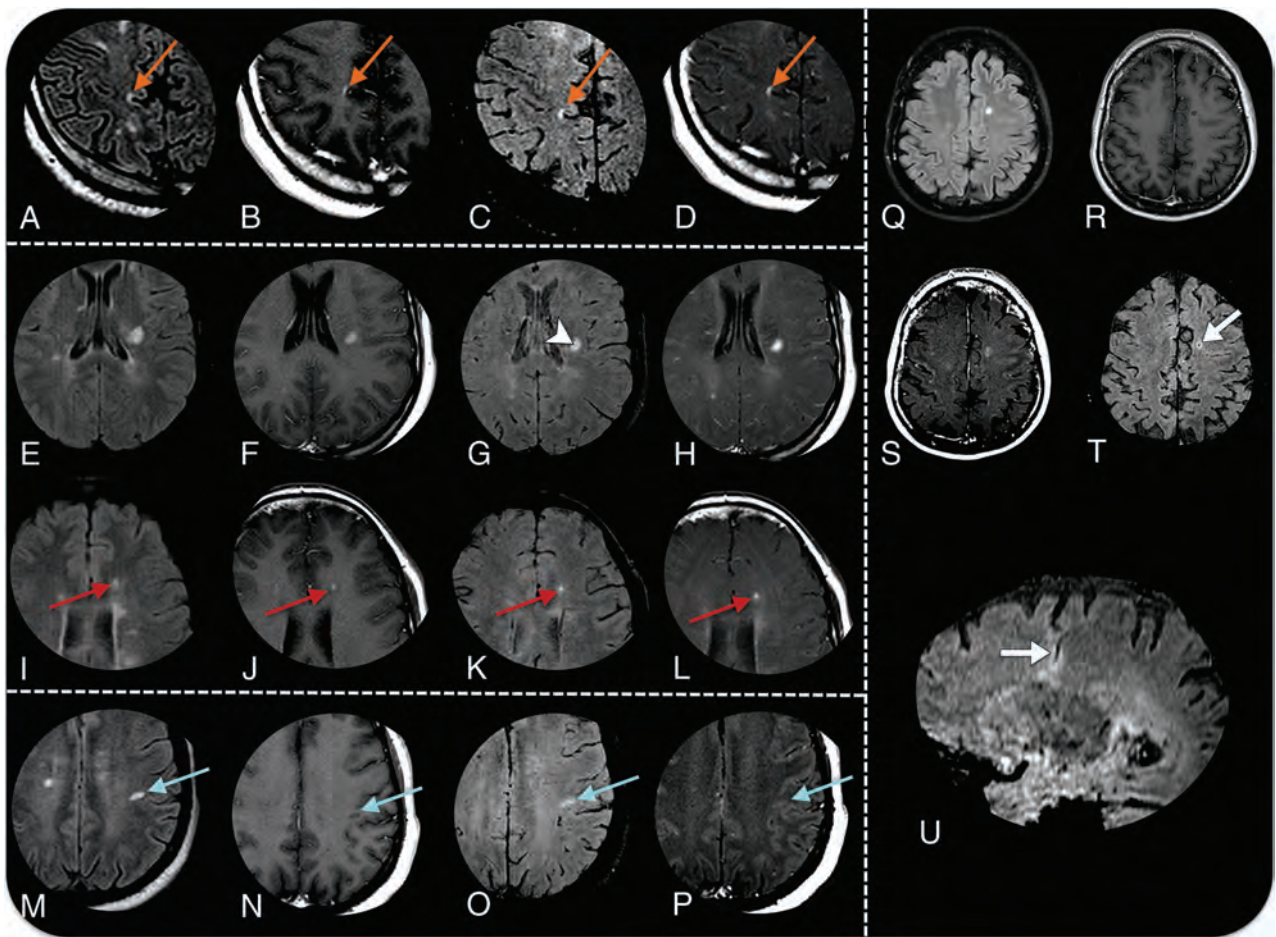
MR imaging detection of active plaques in 4 different patients with MS. Axial fluid-attenuated inversion recovery sequences (A, E, I, M, and Q), axial Gd-T1 SE sequences (B, F, J, N, and R), axial Gd-SWI sequences (C, G, K, O, and T), T1 Gd-T1 MTC sequences (D, H, L, P, and S), and a sagittal reformatting Gd-SWI sequence (U). Patient 1 demonstrates an acute juxtacortical/cortical demyelinating lesion in the right precuneus with Gd enhancement in all sequences (orange arrows in A–D). Patient 2 demonstrates an acute demyelinating plaque on the left corona radiata (E–F). Gd-SWI depicts the central vein within the plaque (arrowhead in G), adding specificity in favor of the demyelinating substrate. Similar to the Gd-T1 SE and Gd-T1 MTC sequences, the Gd-SWI sequence is also able to demonstrate BBB dysfunction in small lesions (red arrows in I–L). Patient 3 shows an acute demyelinating plaque on the subcortical white matter of the left postcentral gyrus that is only characterized by the Gd-SWI sequence (blue arrows in M–P). Patient 4 has a venous developmental anomaly in the left semiovale center, surrounded by a parenchymal hyperintensity on a FLAIR sequence (Q). Both the Gd-T1 MTC and Gd-SWI sequences (S and T) demonstrate a faint enhancement (arrow in T), which is elegantly demonstrated by the sagittal reformatting Gd-SWI sequence (arrow in U).
